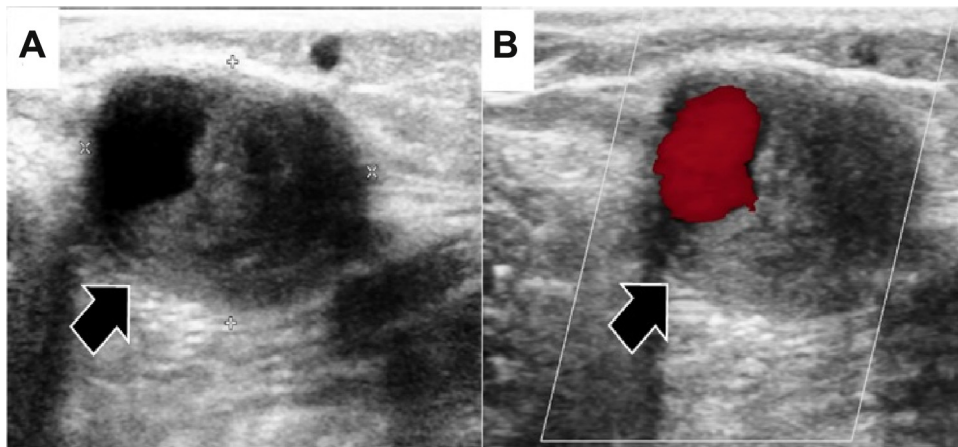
Aneurysmal degeneration of lower extremity autologous vein graft demonstrated on grayscale (A) and color (B) ultrasound.
